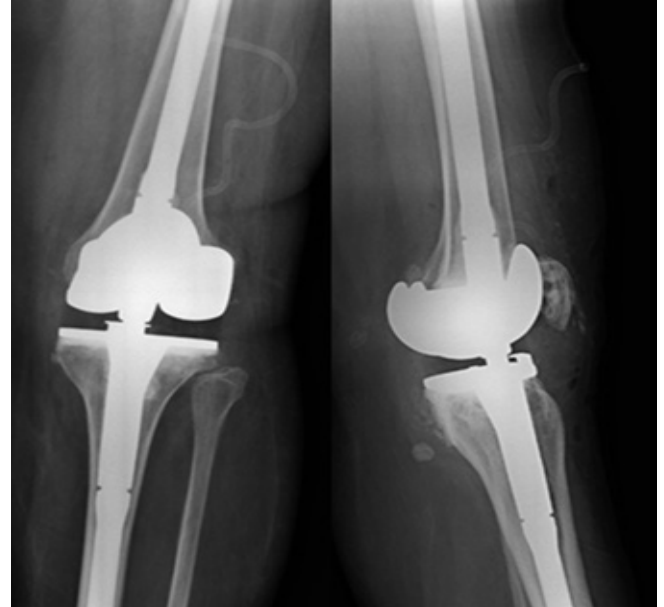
Post operation X-ray of left knee after total knee arthroplasty with long stem rotating hinge prosthesis.
